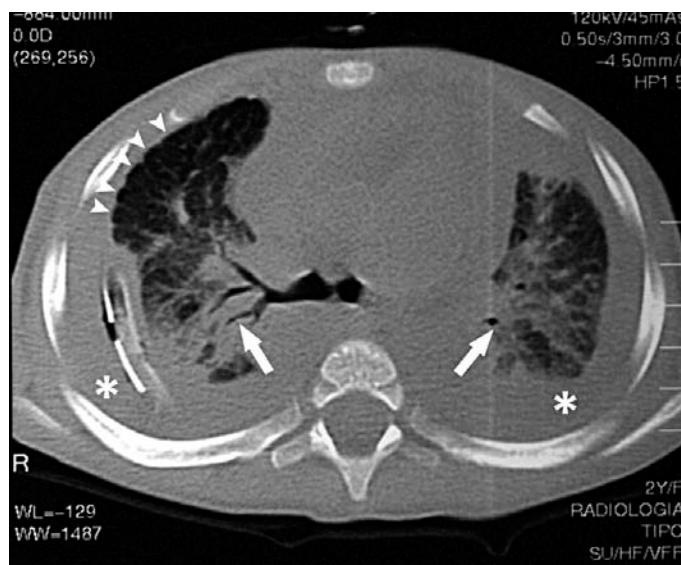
Pulmonary Lymphangiectasia. HRCT.
